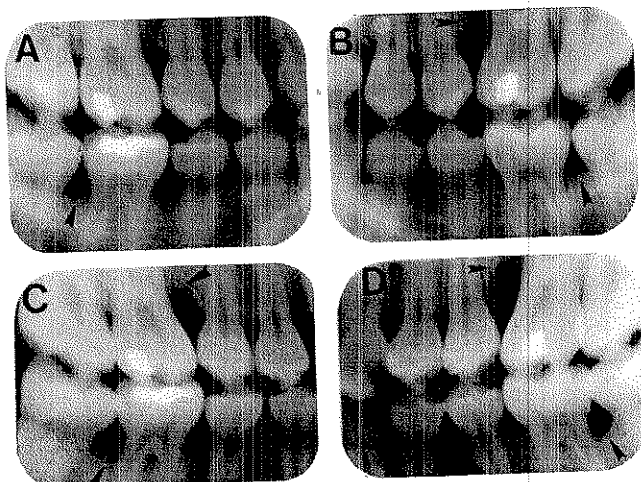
Case #1, bitewing radiographs revealing progressive bone loss (arrows) on mesial of maxillary and distal of mandibular first molars. A,B, April 1974. C,D, June 1975.
